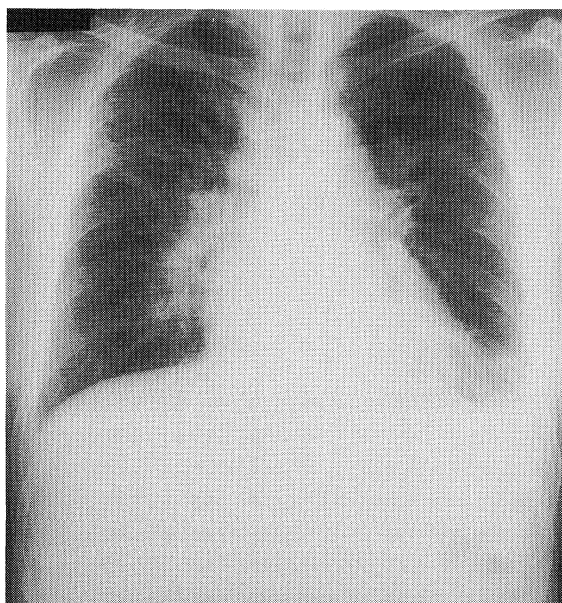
Chest X-ray on admission shows diffuse reticular shadows in the bilateral lung fields, and hilar lymphadenopathy.
